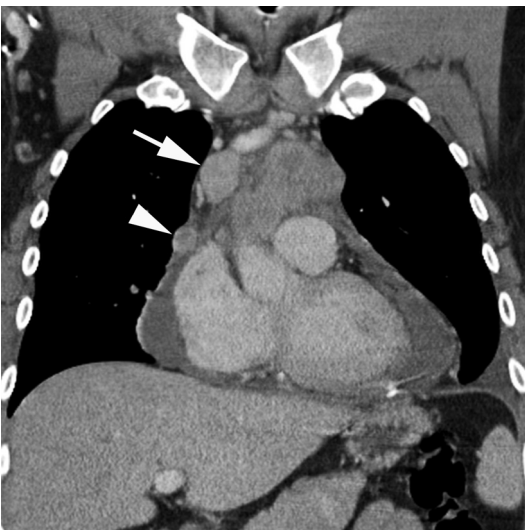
Thymic carcinoma. Contrast-enhanced coronal CT shows a heterogeneously enhancing, necrotic prevascular mediastinal mass with lymphadenopathy (*arrow*), solid pericardial metastasis (*arrowhead*), and a pericardial effusion.
